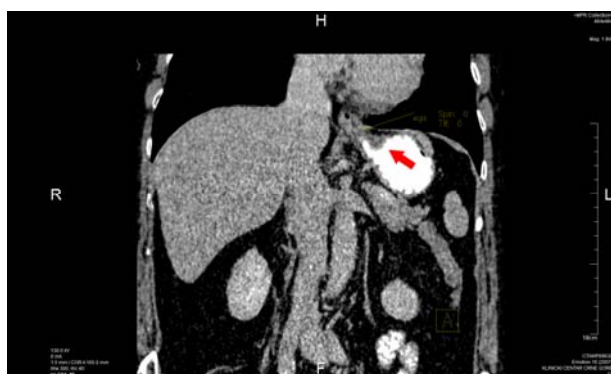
Multislice computed tomography (MSCT) with contrast showed unclear picture of tumorous lesion (red arrow) in gastric wall, near esophagogastric junction.
